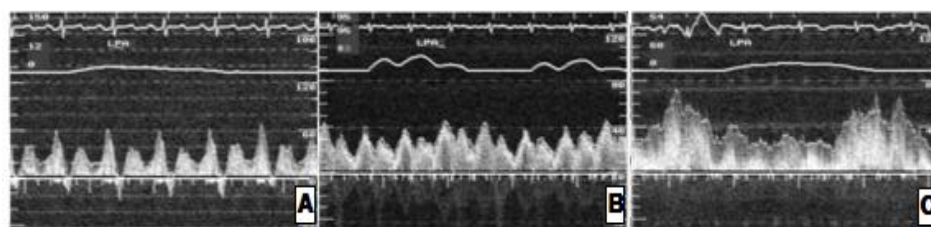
Intravascular Doppler spectrals at LPA in 3 groups (A;APC group, B;LTF group, C;ECF group)
